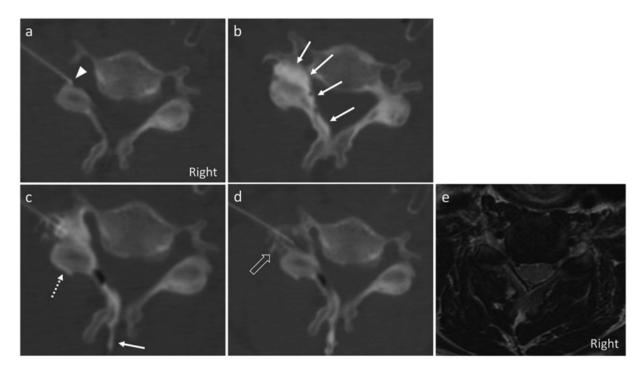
Patient 1. CT-guided left C5–C6 transforaminal epidural steroid injection in a 44-year-old male with left C6 radiculopathy. Precontrast axial image (a) shows the needle tip in the posterolateral left C5–C6 neural foramen (arrowhead). After injection of about 2 mL of diluted iohexol 300 mgl/mL, contrast appears to fill the foramen with central epidural flow (b, arrows). However, a more inferior image shows that most of this flow is actually within the retrodural space of Okada posterior to the ligamentum flavum and extending into the interspinous region (c, arrow) and partially filling the C5–C6 facet (c, dashed arrow). The needle tip was repositioned, and subsequent contrast injection shows peripheral and foraminal epidural flow (d, open arrow). Corresponding axial T2-weighted magnetic resonance image at the level of the injection (e).
